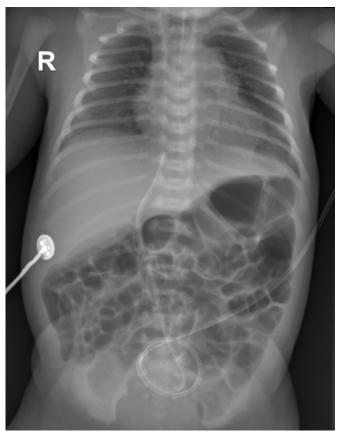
Thoracoabdominal radiography on Day 1 showing bilateral granular pulmonary opacities and moderate enteral air distension.
